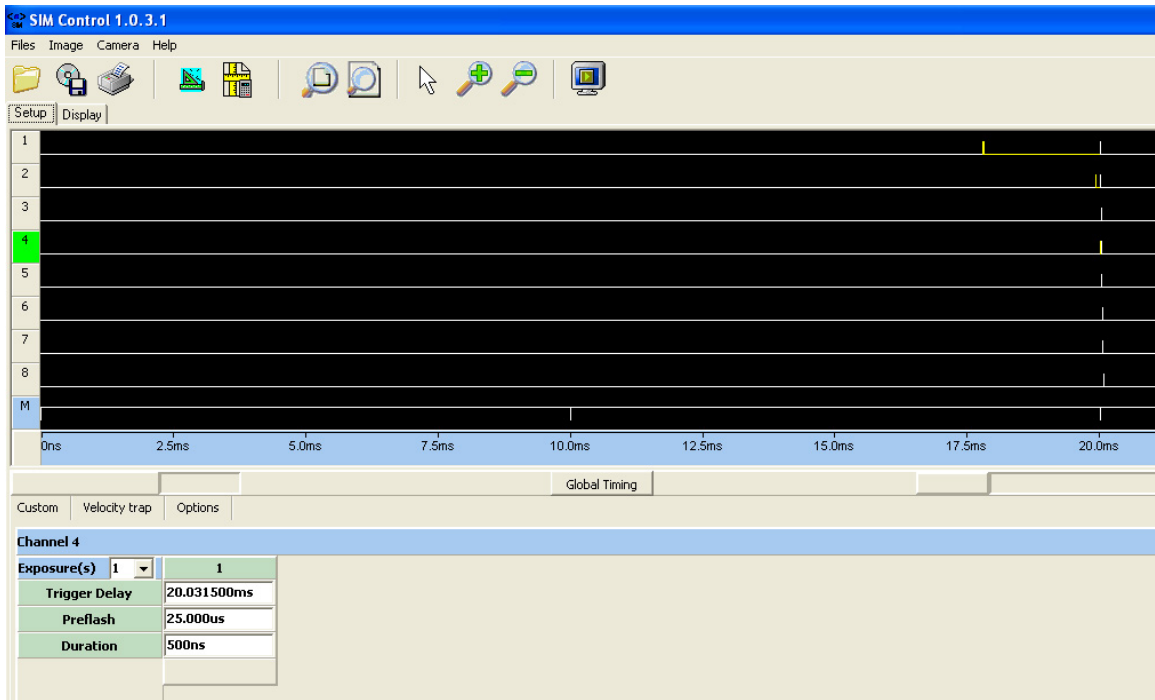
Example of a timeline in the SIM camera software. The positions of the different trigger signals, relative to the capture of the first image frame, are respectively : Channel 1, streak camera, -2.2 milliseconds ; Channel 2, flash lamp, -100 microseconds; Channel 4, ultrasound, -25 microseconds (yellow vertical lines on the timeline represent triggers while white vertical lines represent frame images).
